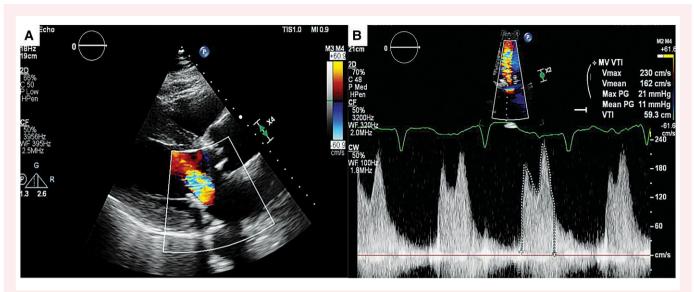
(A) 2D transthoracic echocardiography image showing the bioprosthetic mitral valve with severe mitral stenosis. (B) Transthoracic echocardiography continuous wave Doppler displaying severe bioprosthetic stenosis.
